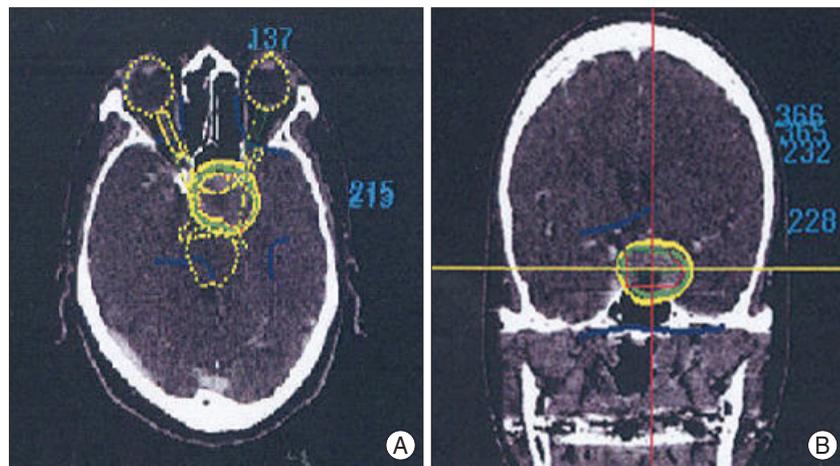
Case 7. Axial computed tomography scan (A) and coronal reconstruction (B). Dose planning with the CyberKnife treatment planning software. Tumor margin, optic nerves, chiasm and tracts are delineated, and the radiation-sensitive optic apparatus is kept out of the high isodose areas. Red lines, tumor; yellow lines, vital structures; green lines, the 80% isodose.
